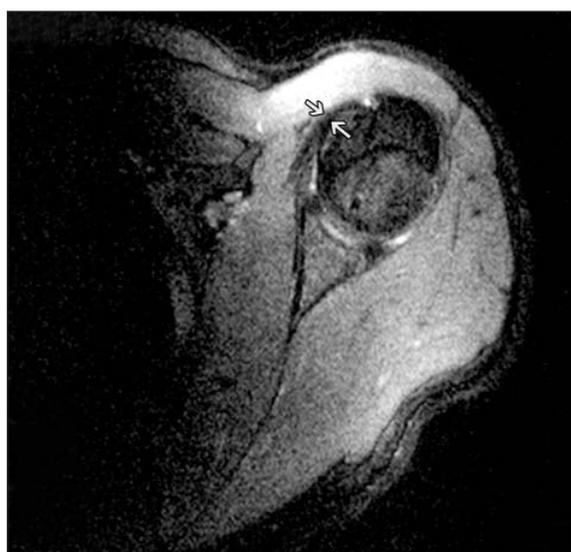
Axial MR image shows improving on subscapularis tendon.
